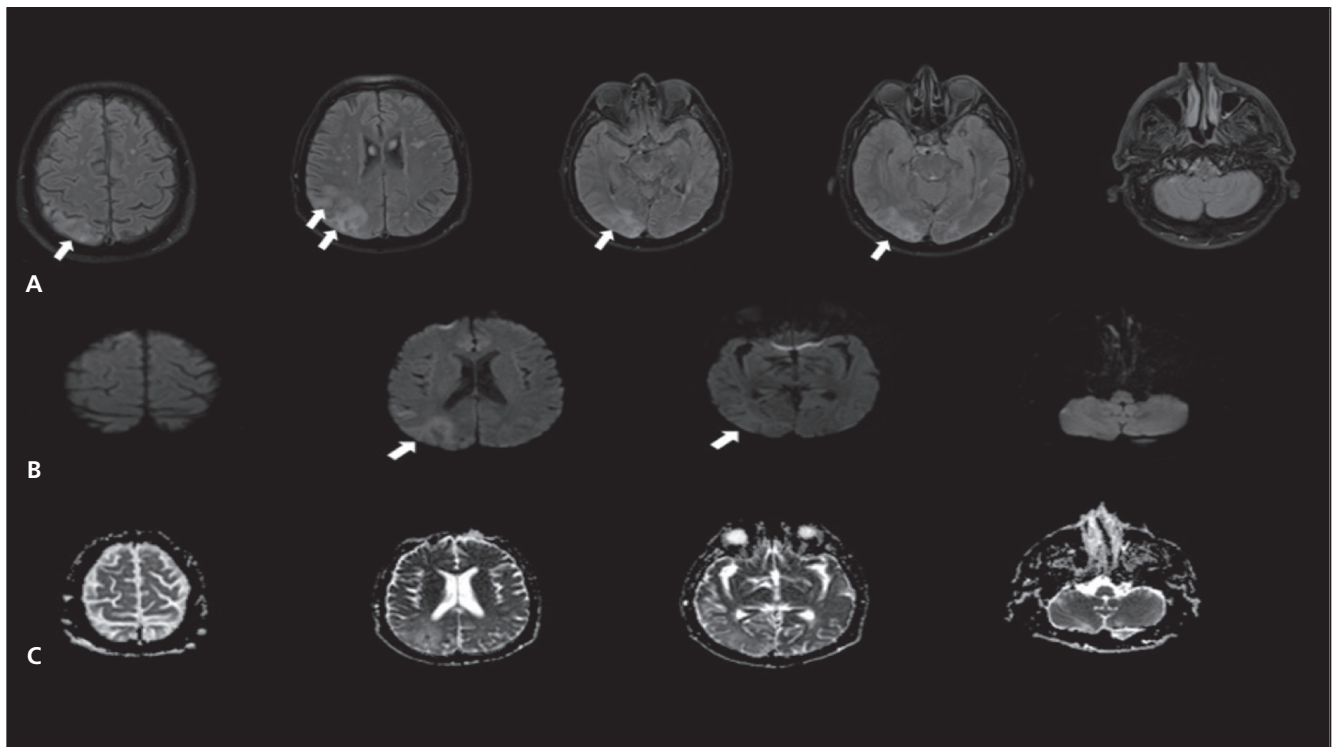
Images on cranial MRI of a 71-year-old man with PRES at follow-up. (A) Axial T2-weighted FLAIR images after three weeks showed a significant regression in the hyperintensity signal areas reflecting vasogenic brain edema. (B, C) Control images after three weeks show a substantial reduction in vasogenic edema.
